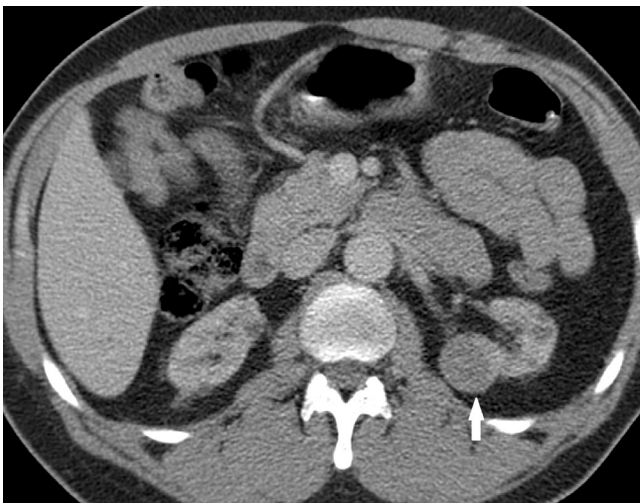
■ Renal cell carcinoma in the non-functioning kidney. Single-phase post-contrast CT through the native kidneys in a patient with a renal transplant demonstrates a small left-sided renal mass which was confirmed as a solid lesion on US and subsequently resected and confirmed as a renal cell carcinoma. Native non-functioning kidneys demonstrate poor enhancement post-contrast and it can be difficult to differentiate a complex cyst from a poorly enhancing tumour.
